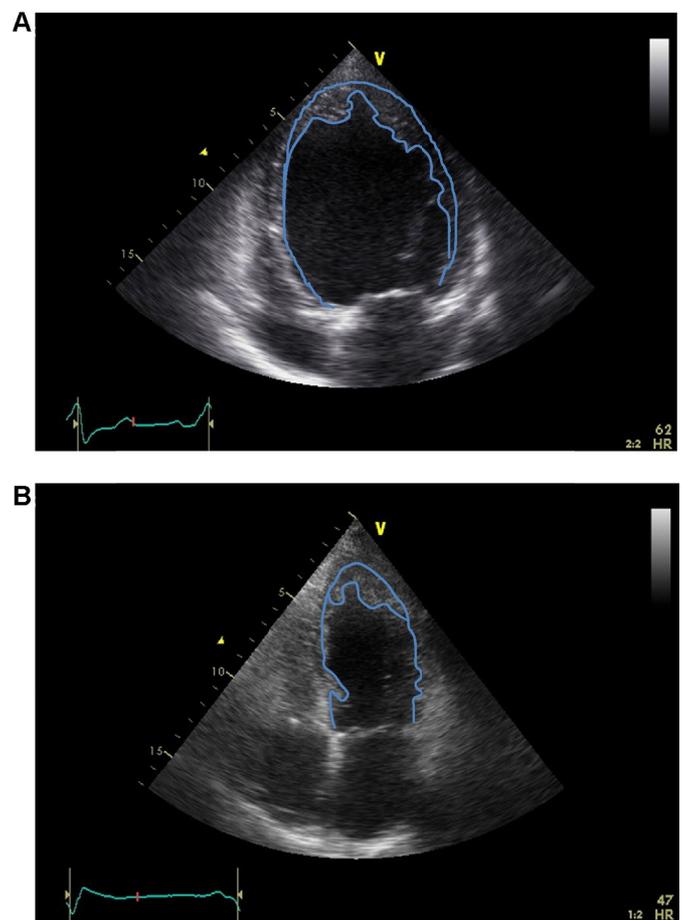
Representative example of echocardiographic measurement of left ventricular hypertrabeculation area in apical four-chamber view (A) at baseline and (B) at 6 months' follow-up. (LV Hypertrabeculation Area) = (The Outer Edge of LVHT) - (The Inner Edge of LVHT). LVHT, left ventricular hypertrabeculation.
